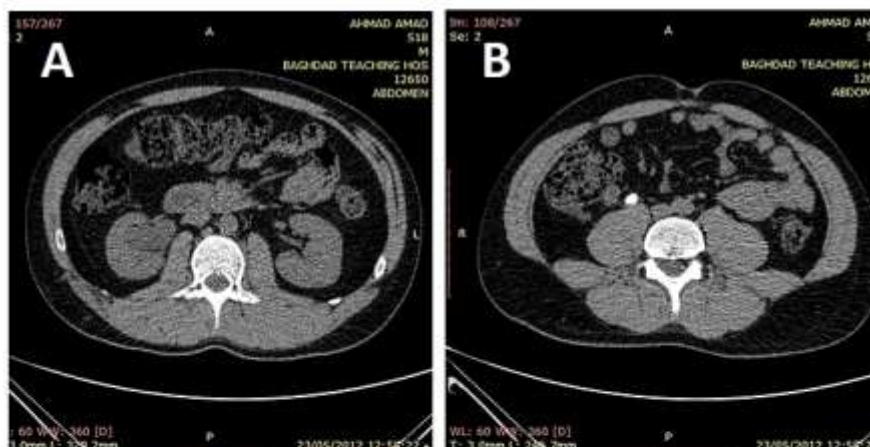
Low dose contrast enhanced CT, A: native phase: moderate Hydronephrosis in right kidney, B: native ,stone in right ureter C: volume rendered 3 D reconstruction, D: MIP in excretory phase
